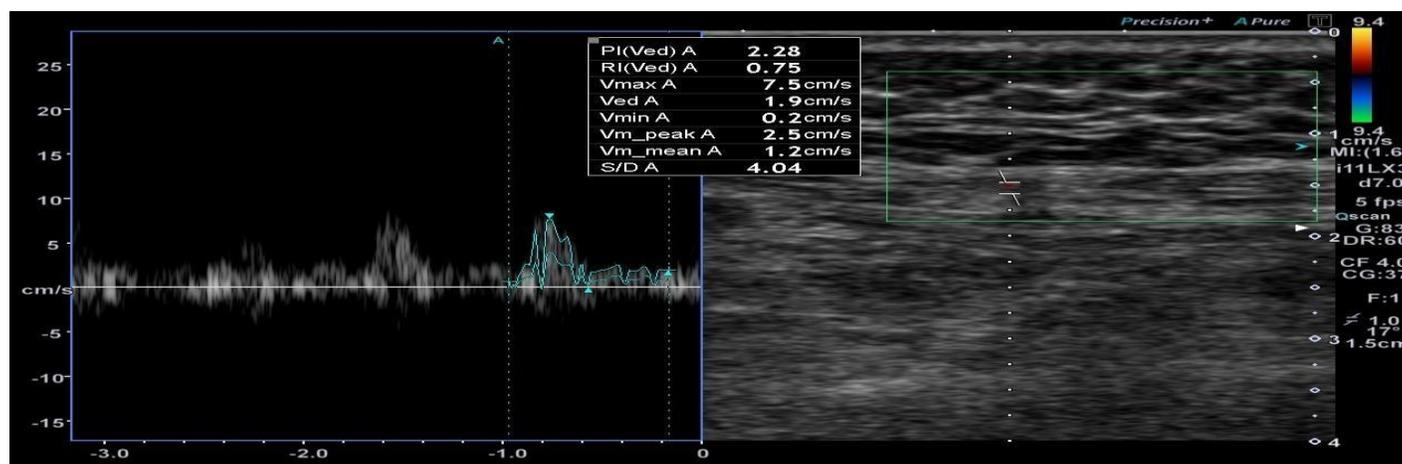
Duplex ultrasound of a perforator artery of Case 2. The waveform analysis showed a peak systolic velocity of 7.5 cm/s, a pulsatility index of 2.28, and a resistance index 0.75.
